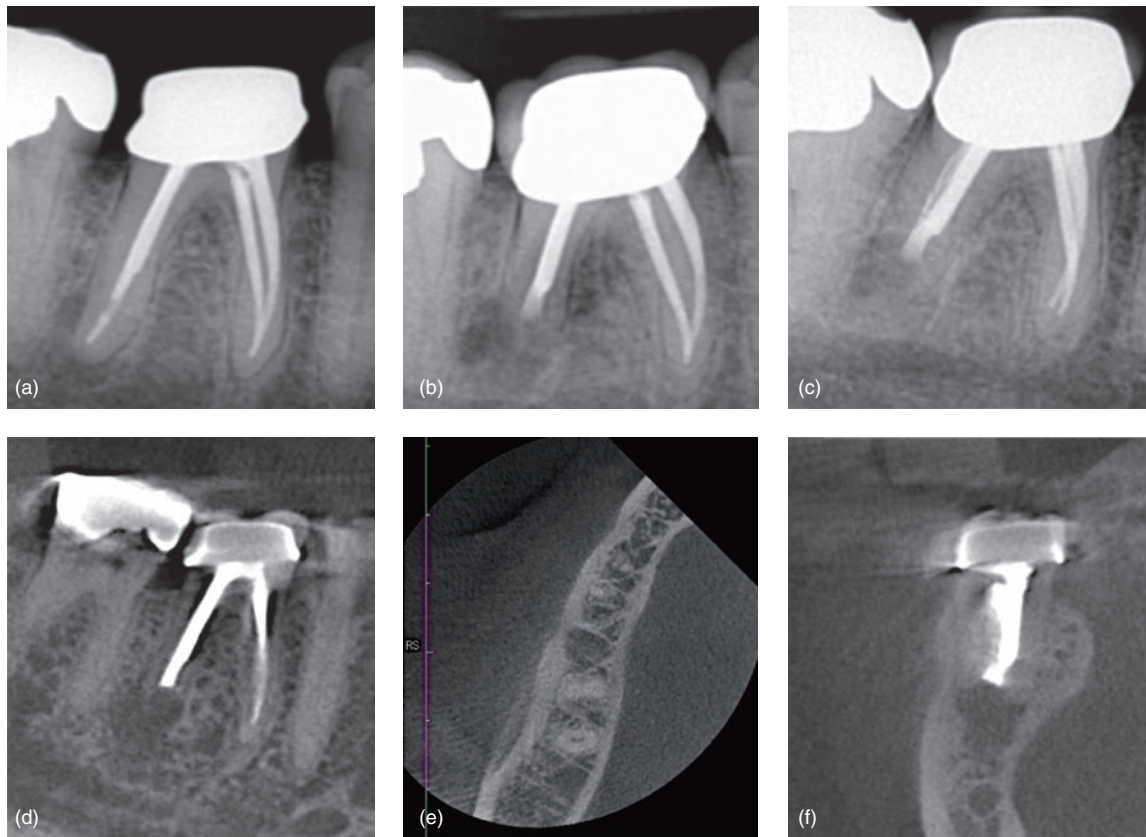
Comparison of two-dimensional (2D) versus three-dimensional (3D) analysis after surgery on the distal root of a first right mandibular molar: (a) preoperative radiograph; (b) postoperative radiograph; (c) 1 year follow-up, classified as uncertain healing according to Molven's criteria (2D); (d) 1 year follow-up CBCT sagittal view, classified as limited healing according to PENN 3D Criteria (note that the complete bone fill within the previous osteotomy is in direct contact with the resected root surface and root end filling material, but is of lower bone density in comparison to the original mature bone surrounding the osteotomy); (e) axial view (3D); (f) coronal view (3D).
